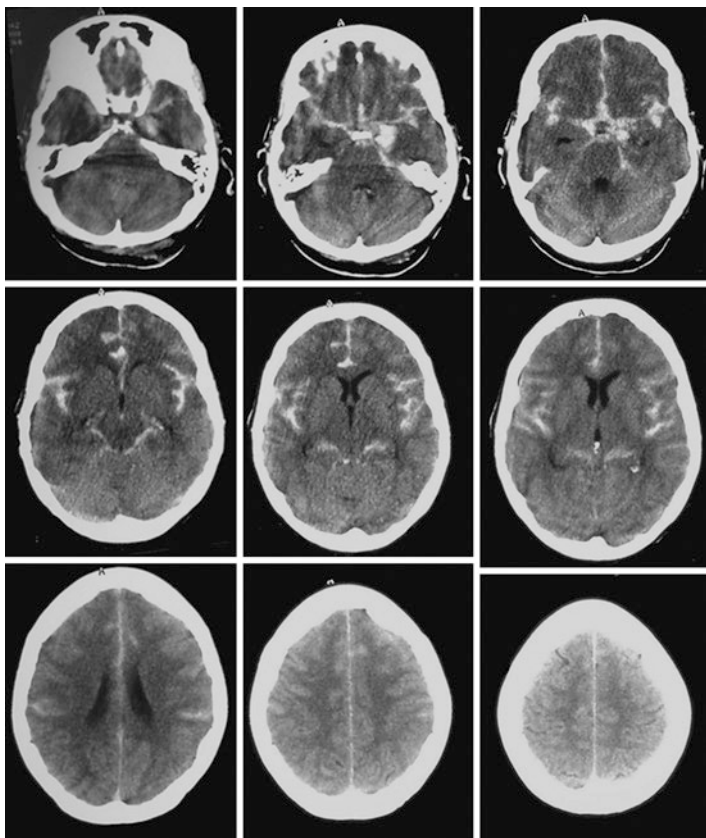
Non-contrast CT scan showing widespread SAH. Note the symmetrical outline of the left and right sylvian fissures and how the blood has outlined all the basal CSF spaces
